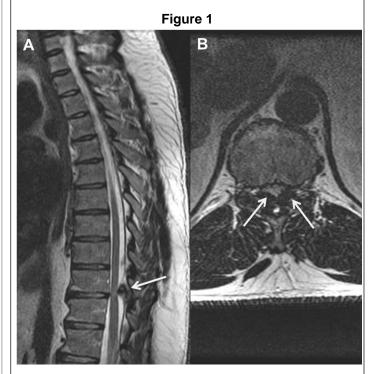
Sagittal (A) and axial (B) T2 MRI showing ligamentum flavum hypetrophy (white arrows), with cord compression and cord signal change.
